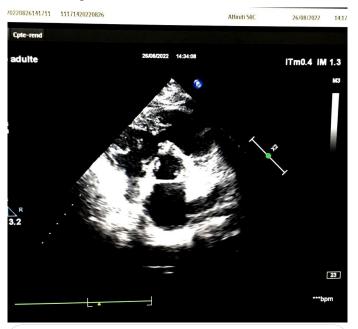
Echocardiography, parasternal short axis, 2D incidence showing mid-ventricular stenosis of the RV with a letter eight aspect.
